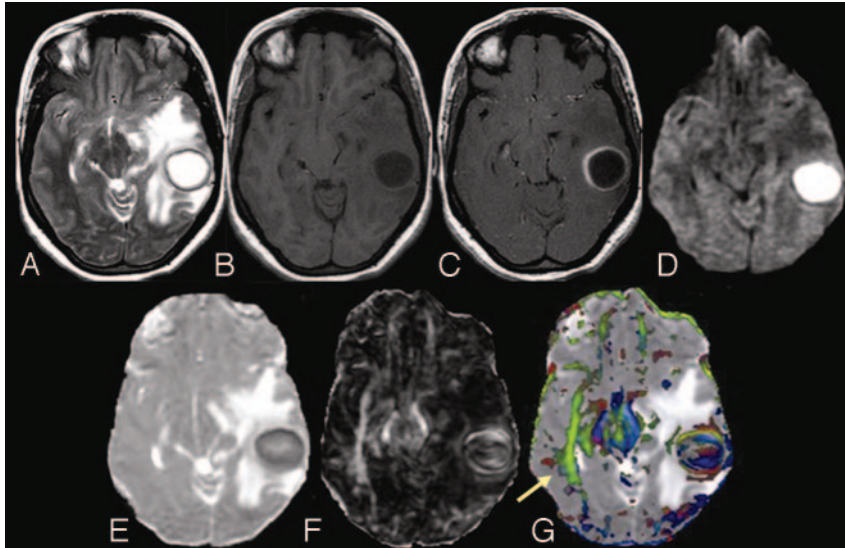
A 31-year-old female patient presenting with pyogenic brain abscess in the left temporal lobe. *A*, Axial T2-weighted image shows a well-defined hyperintense lesion with a hypointense wall. *B*, The lesion appears hypointense on the axial T1-weighted image with an isointense wall. *C*, On the postcontrast T1-weighted image, the lesion shows ring enhancement. *D*, DWI shows homogeneous hyperintensity in the cavity that appears hypointense on the MD map (*E*). The FA (*F*) and red-green-blue color-modulated FA map fused with the MD map (*G*) show that high FA in the abscess cavity is similar to what is observed in the contralateral inferior longitudinal fasciculus and midbrain (arrow).
